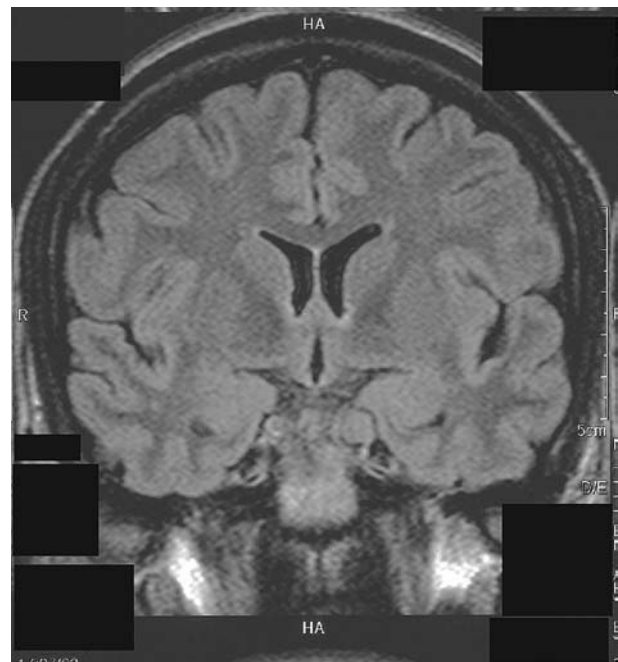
An MR (FLAIR) scan four months after gamma knife surgery shows the residual hypophyseal adenoma, but no new pathological lesions
